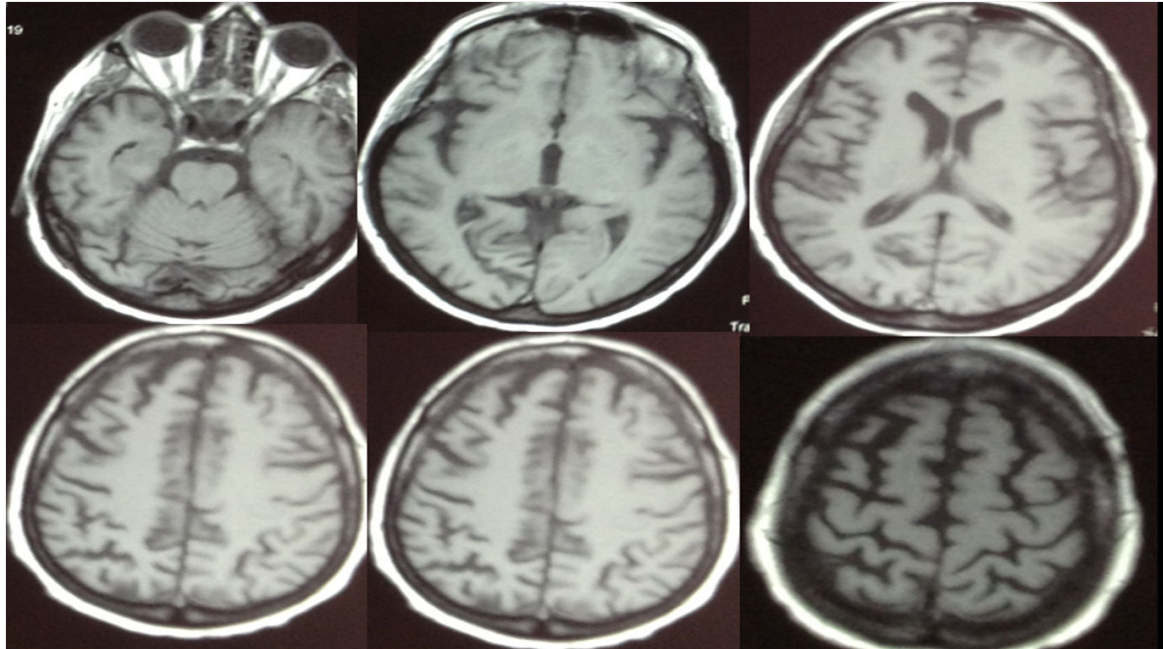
MRI scan performed at admission.
